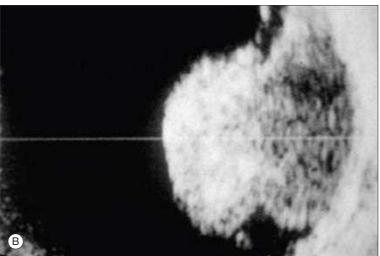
B-Scan Ultrasonographic Images of Choroidal Melanoma That Have Erupted Through Bruch's Membrane. (A) Tumor with small base and relatively large apical cap. (B) Tumor with a biconvex cross-sectional base and relatively large apical cap. Note that the base of each tumor is relatively hyporeflective while the apical cap is more brightly sonoreflective.
